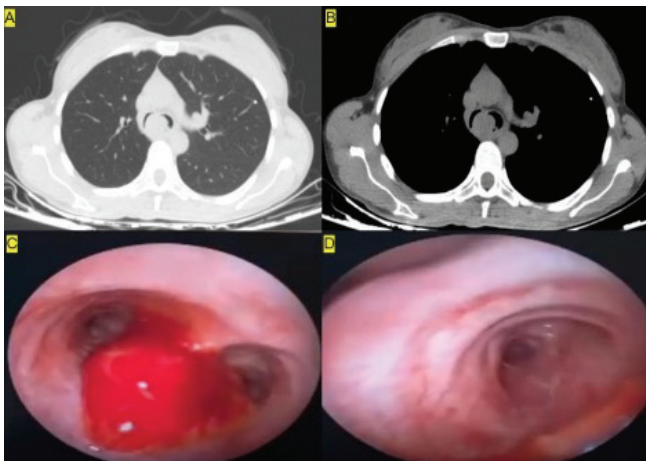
Right VATS Segmental Sleeve Resection of the Right Main Bronchus. A: Thoracic CT of endobronchial tumor localized in the right main bronchus, B: Fiberoptic bronchoscopy images of endobronchial tumor localized in the right main bronchus, C: Glomus tumor in the right main bronchus, D: Sleeve anastomosis of the right main bronchus.
